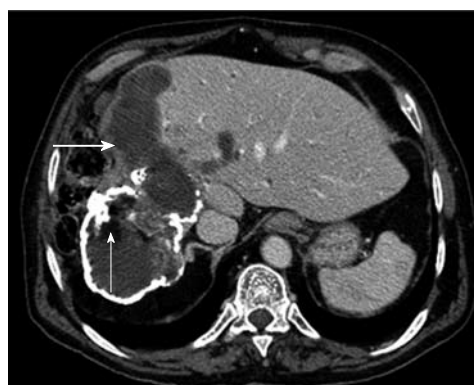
Contrast-enhanced upper abdominal computed tomography scan demonstrates a partially calcified hydatid cyst in direct communication with the biliary tree markedly dilated (the bold white arrow). The presence of fat components within the cyst derives from the lipid elements in bile (the thin white arrow) (type IV).
